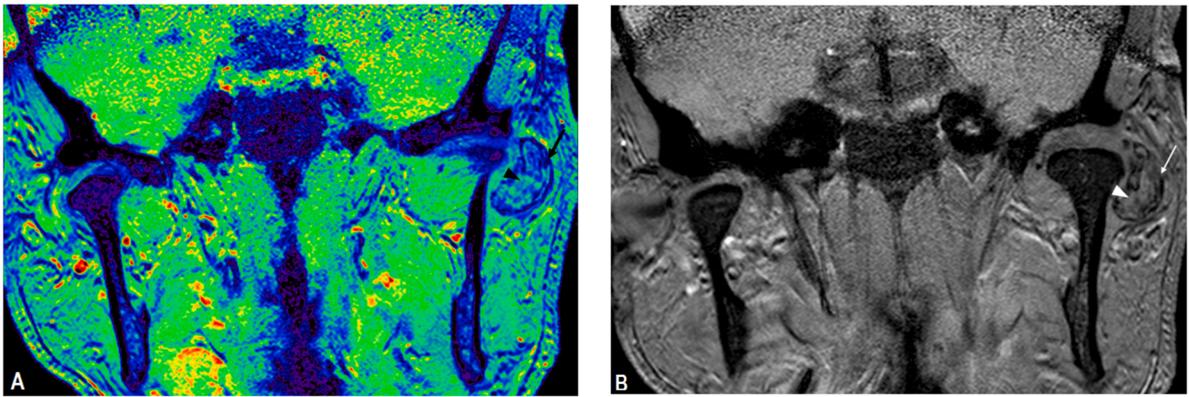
A and 1B - Magnetic resonance imaging of the left TMJ in a T1-weighted coronal view, showing an oval-shaped lesion, surrounded by a low-signal halo (arrow) and presenting a heterogeneous component compatible with high-signal calcifications (arrowhead). (A) Post-processed MRI by dynamic color enhancement.
